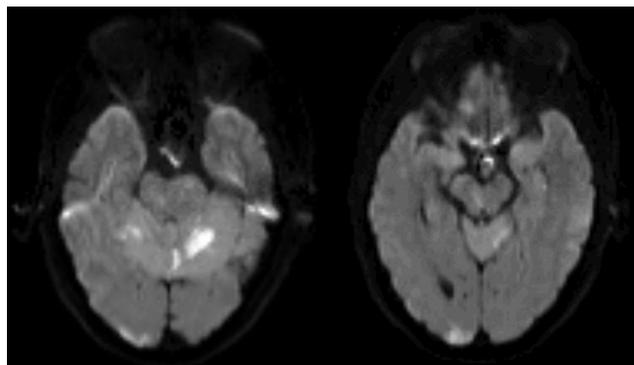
MRI axial diffusion-weighted imaging (DWI) showing hyperintensity (diffusion restriction) in the cerebellum, right occipital lobe, and right paramedian midbrain.
